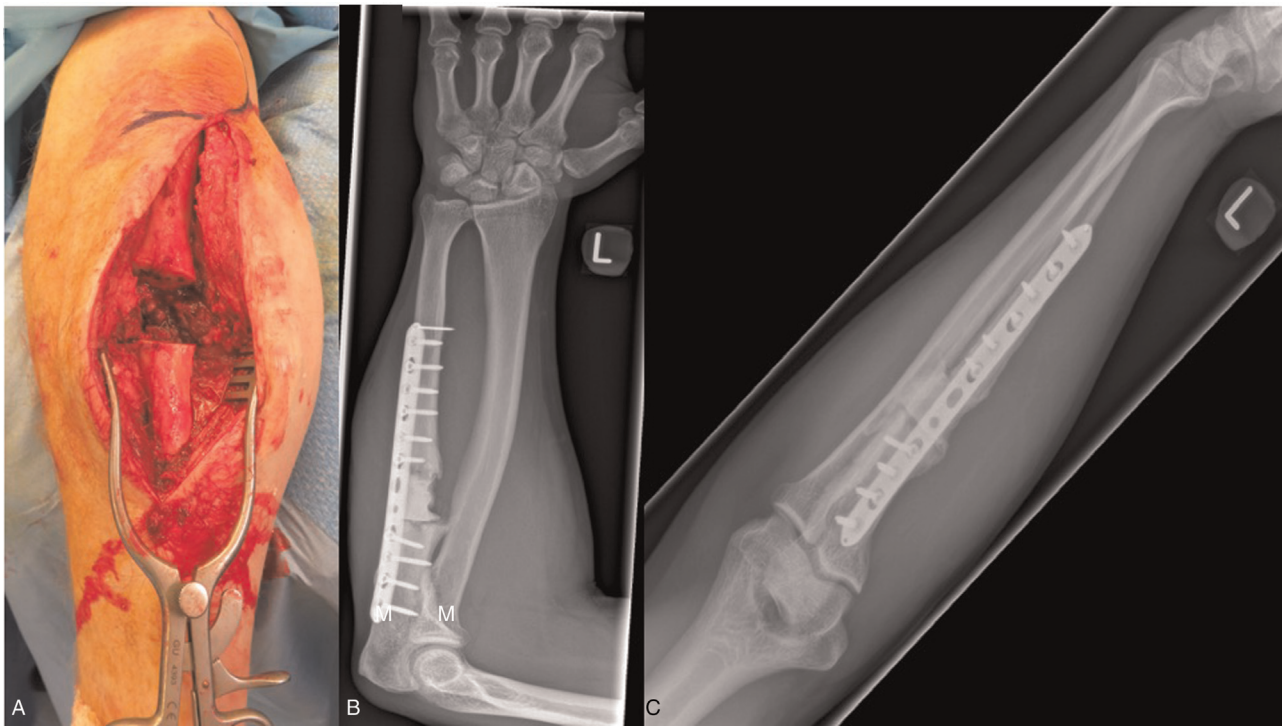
(A) Intraoperative photograph demonstrating the bone defect created following radical debridement of the infected bone edges. (B) AP and (C) lateral postoperative radiographs demonstrating reconstruction of ulna and cement spacer in the area of the defect (first-stage Masquelet technique).
